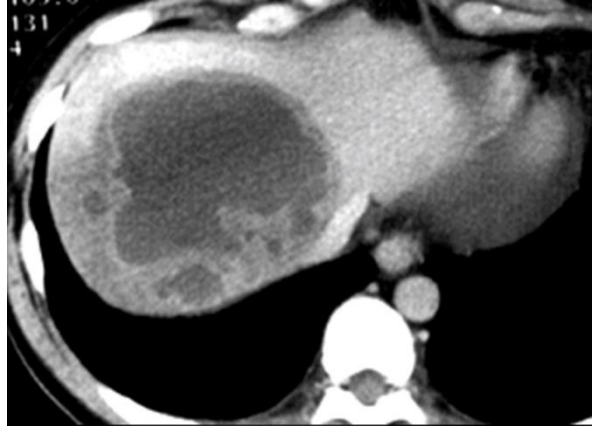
Axial CT for Abdomen show liver with Pyogenic abscess .
